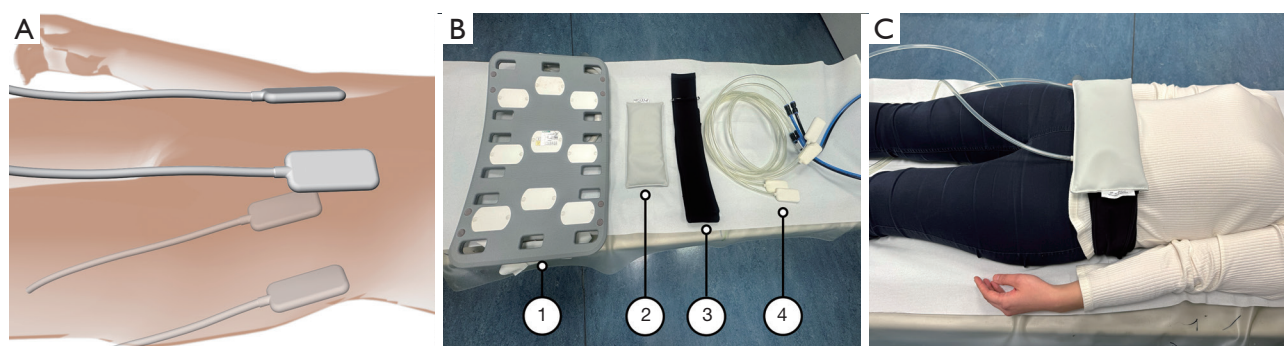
Magnetic resonance elastography driver setup. (A) Two drivers each were placed anteriorly and posteriorly around the lower abdomen. (B) Components: ① magnetic resonance imaging phased-array coil, ② sand-filled cushion, ③ driver belt, ④ four compressed-air drivers with hoses. (C) Placement of components.
